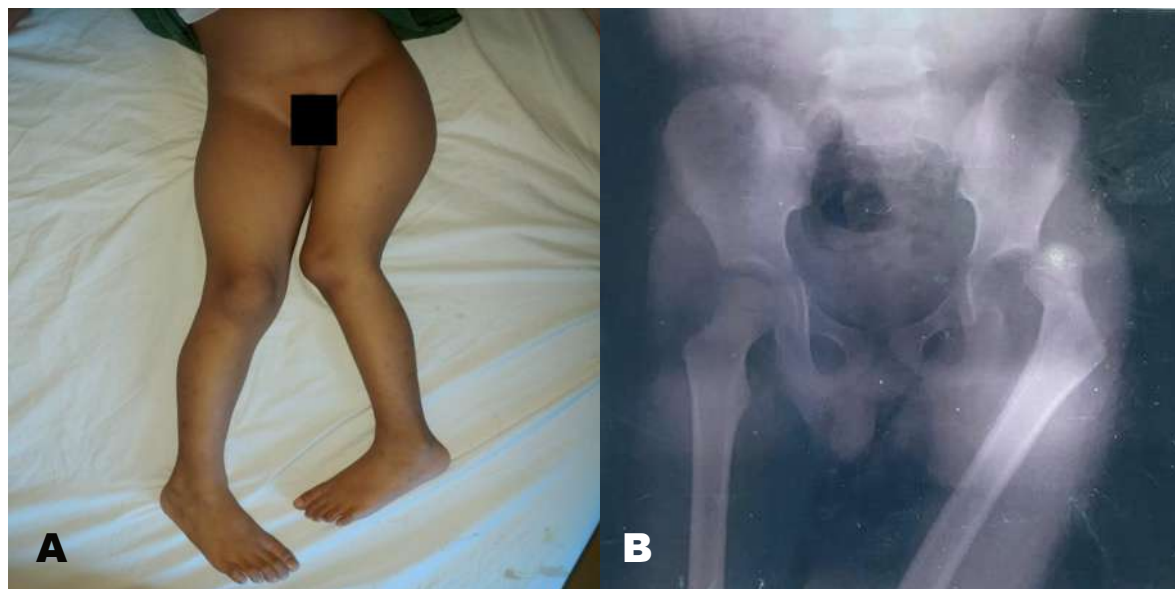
The patient's left hip before reduction (A). A posterior hip dislocation without associated fracture was seen on the AP hip radiograph (B)
